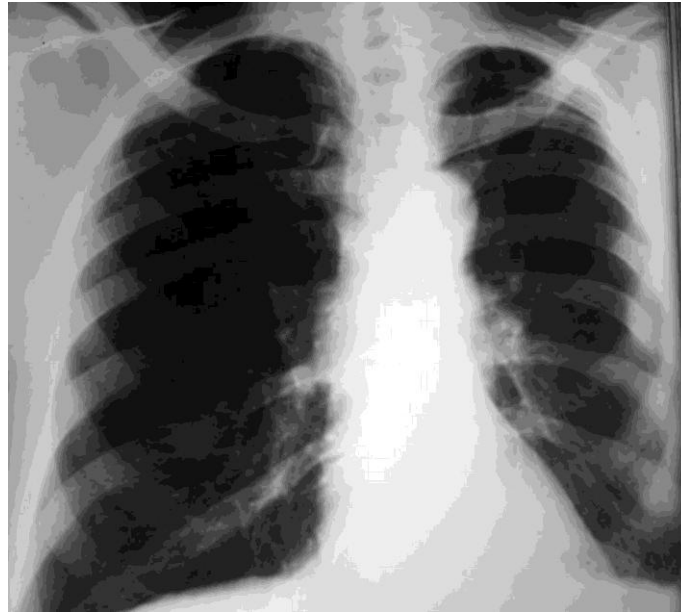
Chest X-ray taken 10 days after trauma shows multiple rib fractures and blunting left costophrenic angle
